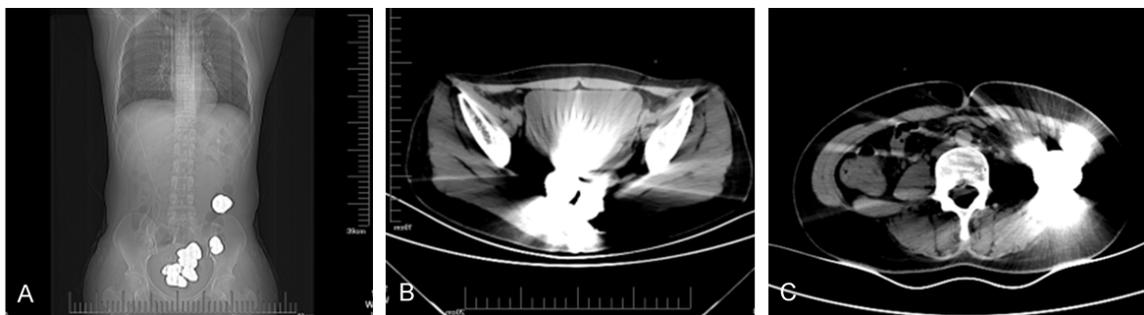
Abdominal CT when the patient was admitted to the hospital (A-C) (see [Table 1](#)).
